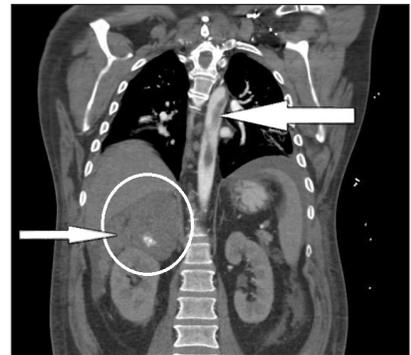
Coronal-view computed tomography image of the patient's chest. The larger white arrow indicates the aortic thrombus. The white circle shows the adrenal mass with calcifications.
